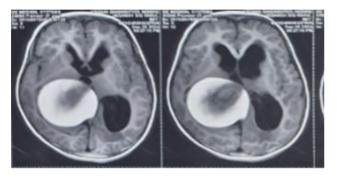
MRI with T1, T2 images, and contrast T1 image.
